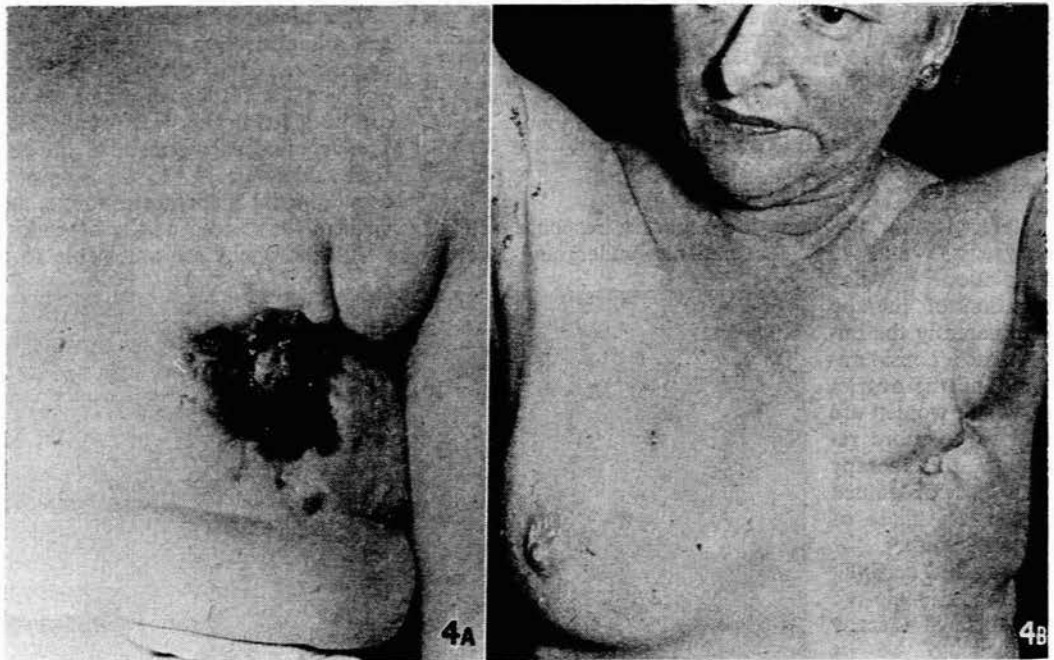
Patient with advanced, fixed, ulcerating growth of the breast. A. Showing the growth. An underlying pleural effusion was also present. B. Two years after a course of deep X-ray and persistent androgen (TPP and durabolin) therapy. This picture shows the degree of healing that took place.
